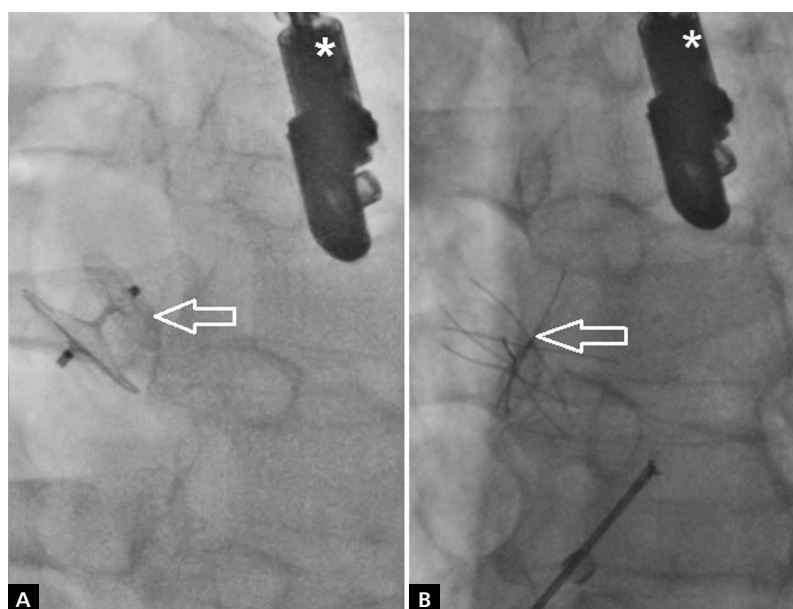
A. Angiography. Patent foramen ovale (PFO) closed with Amplatzer PFO Occluder, St. Jude Medical, 25 mm (arrow); B. Angiography. PFO closed with CARDIA PFO device, 30 mm (arrow); transoesophageal echocardiography probe was marked with an asterisk (*) in panel A and panel B
